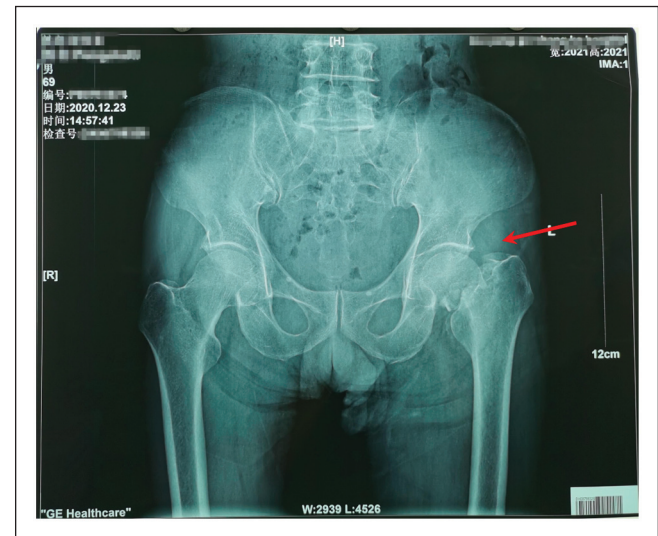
Hip X-ray on 23 December 2020, indicating a left femoral neck fracture (red arrow).
